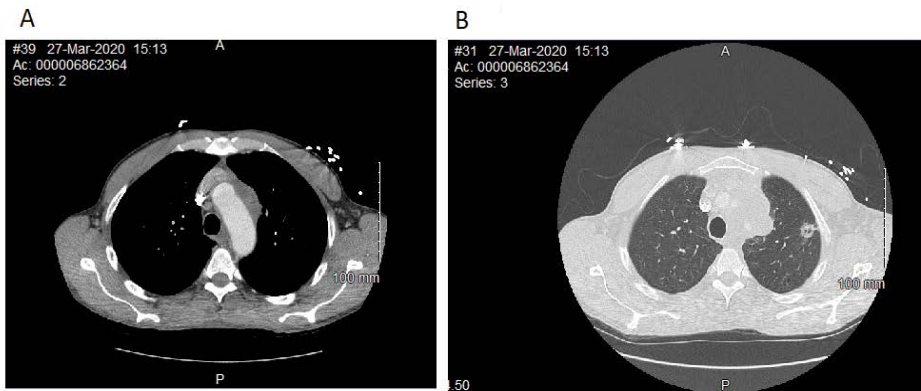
Chest computed tomography revealed left sided lobular mediastinal mass (a) and a spiculated cavitary nodule in left upper lobe (b).
